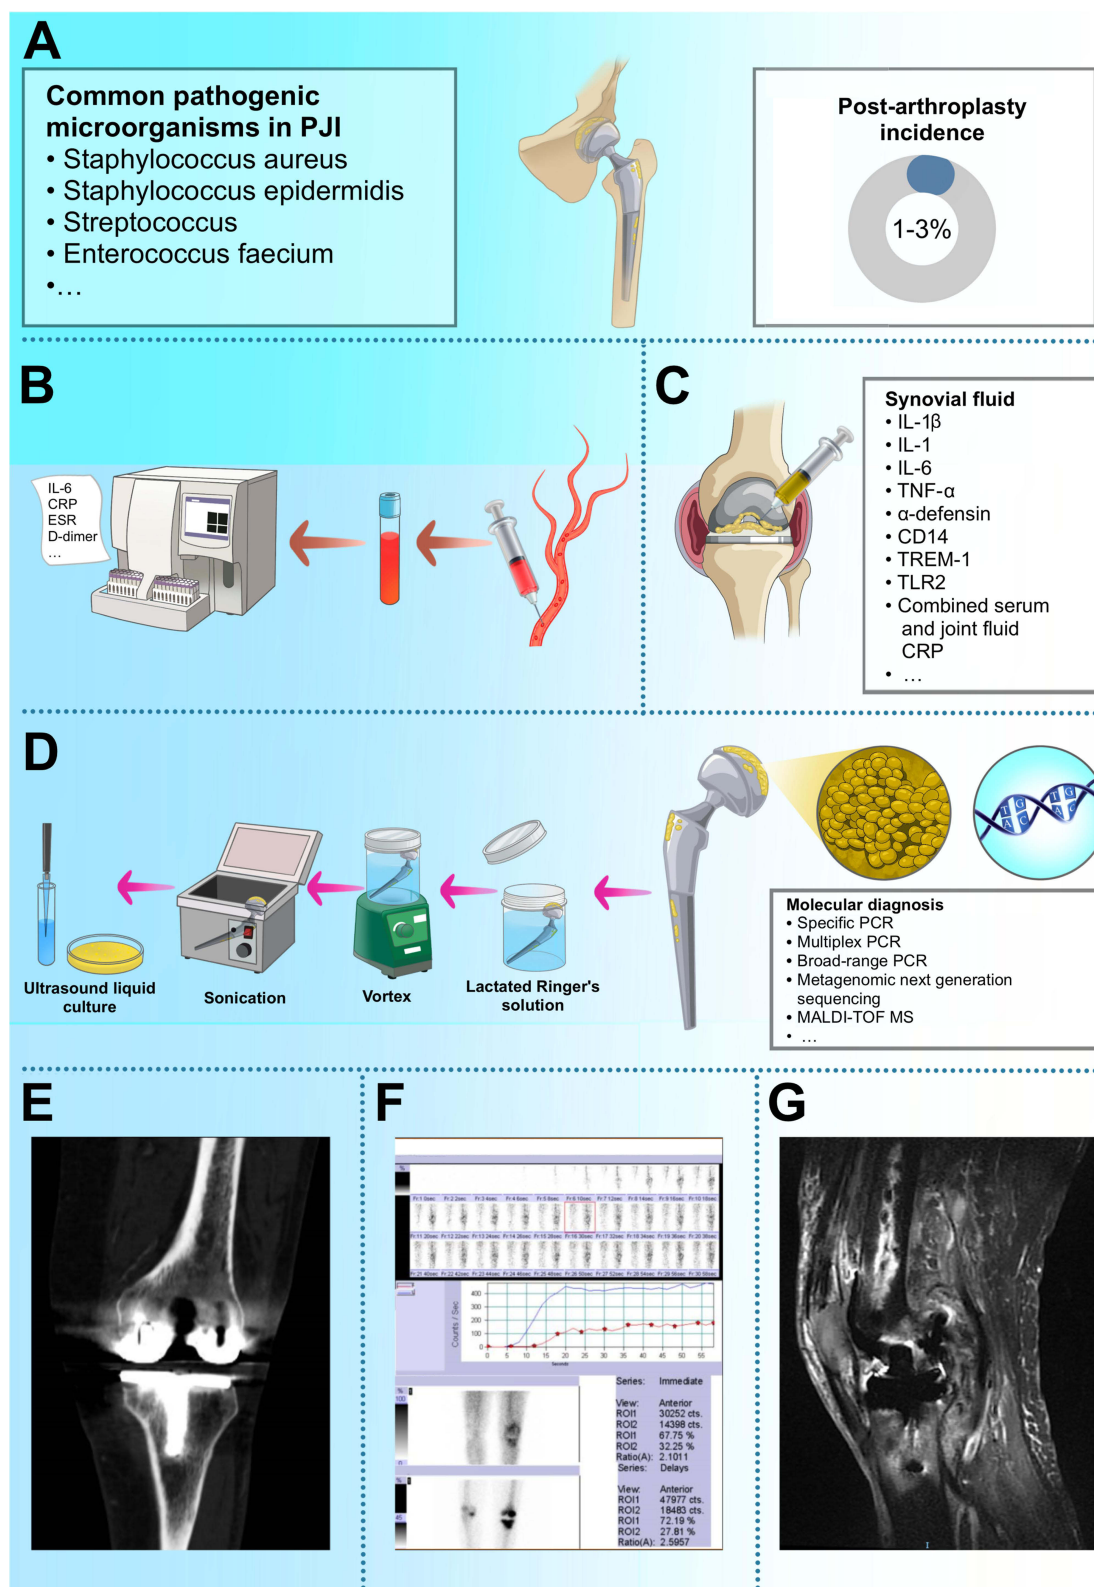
Diagnosis and epidemiology of Periprosthetic joint infection (PJI). (A) Epidemiology of PJI. (B) Molecular biology and Pathogen diagnosis process in PJI. (C) Serologic Testing of PJI. (D) Joint Aspiration and Synovial Fluid Analysis. (E–G) CT/ Bone Scintigraphy/MRI image of PJI patient.
